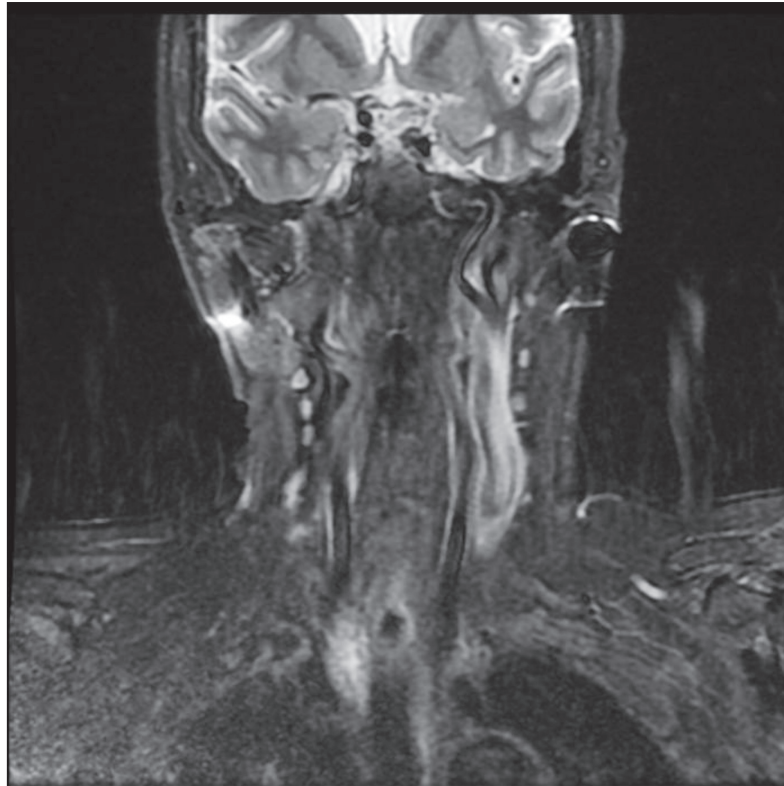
The magnetic resonance images showed remaining upper mediastinal parathyroid adenoma
